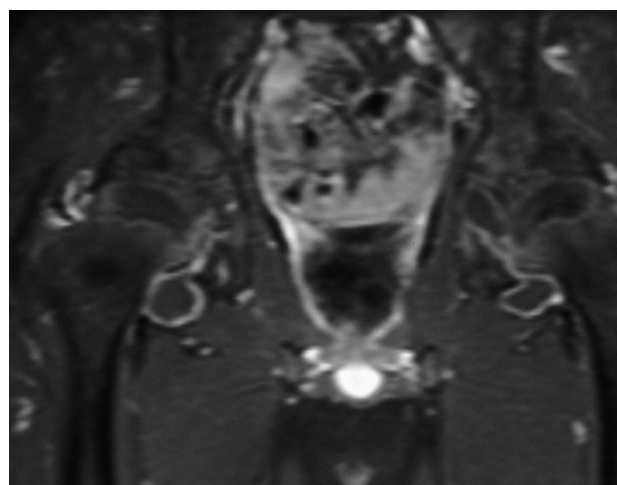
MRI with gadolinium: rim enhancement of joint capsule.
